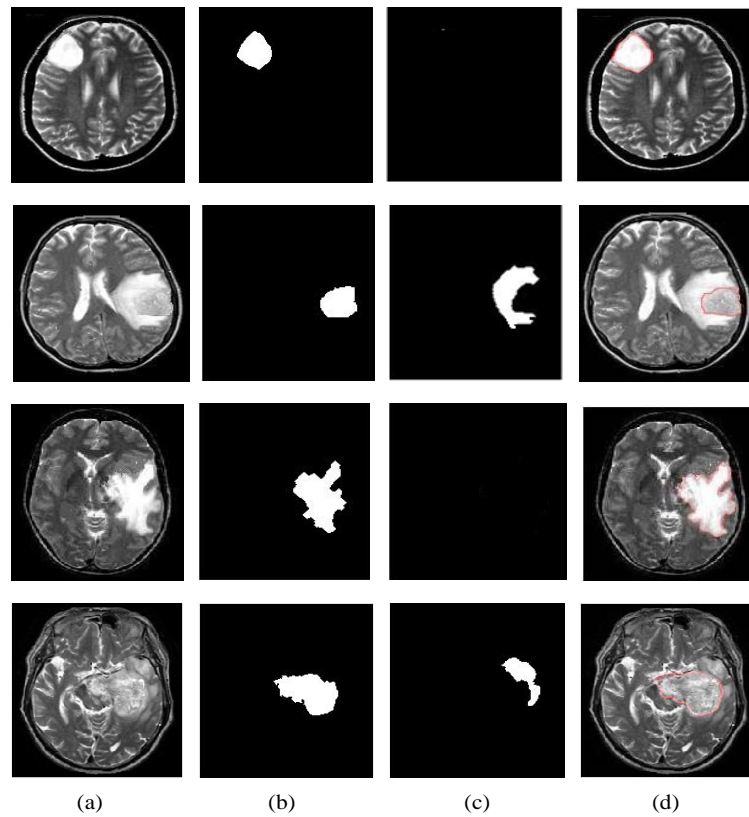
Results of Brain Tumor Segmentation on the MRI Image (a) T2-Weighted Brain MRI Image (b) Brain Tumor (c) Edema (d) Boundary of Brain Tumor on the MRI Image
